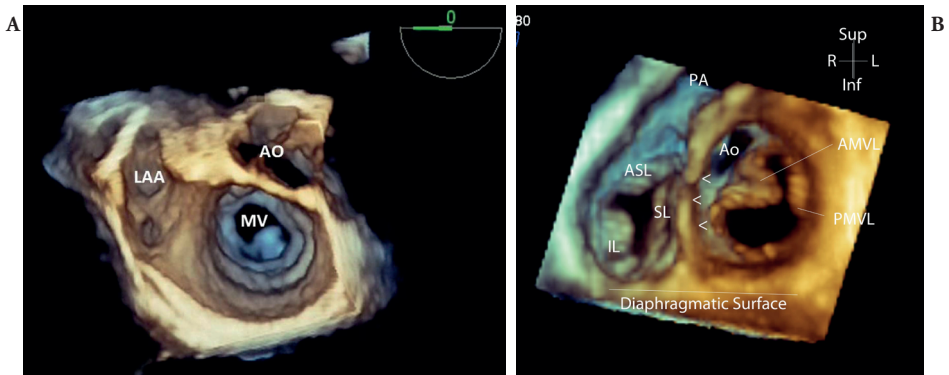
(A) Transoesophageal 3DE view of the mitral valve from the atrial side. The mitral valve, aortic valve and left atrial appendage are visualised from the atrial aspect in an anatomic orientation. If the annulus of the mitral valve is viewed as a clock-face, the aortic valve is at two o'clock with reference to the mitral valve. (B) Transoesophageal 3DE view of the mitral and tricuspid valves from the ventricular side. The mitral and tricuspid valves are viewed from the ventricular aspect in an anatomic orientation. The aorta is at a 10 o'clock position with reference to the mitral valve. The inferior, septal and anterosuperior leaflets of the tricuspid valve are seen in anatomic orientation as well as the curved shape of the ventricular septum. LAA, left atrial appendage; MV, mitral valve; ASL, anterosuperior leaflet of the tricuspid valve; IL, inferior leaflet of the tricuspid valve; SL, septal leaflet of the tricuspid valve; PA, pulmonary artery; Ao, aorta; AMVL, anterior mitral valve leaflet; PMVL, posterior mitral valve leaflet.
